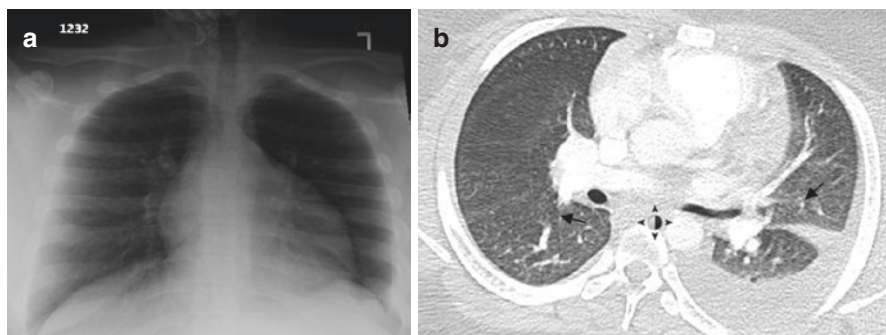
(a) Chest x-ray shows small airway disease, with bilateral perihilar patchy opacities. (b) Axial CT with contrast of the chest showed multiple bilateral subsegmental filling defects (arrows) within the pulmonary arteries, including the right and left upper lobes. A pleural effusion is present on the left
